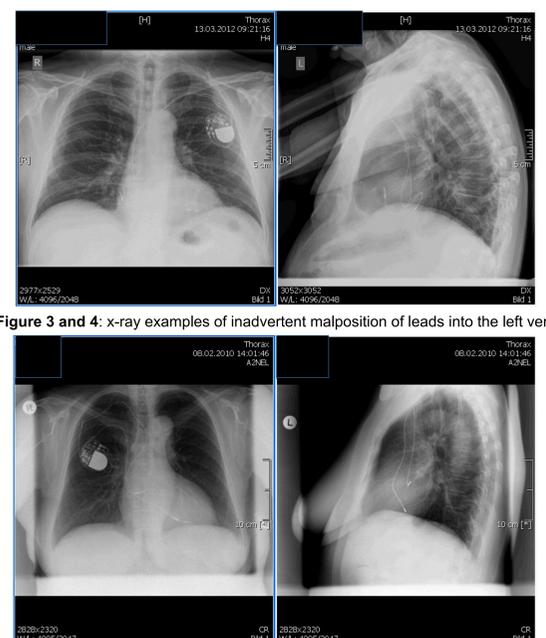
x-ray examples of inadvertent malposition of leads into the left ventricle
